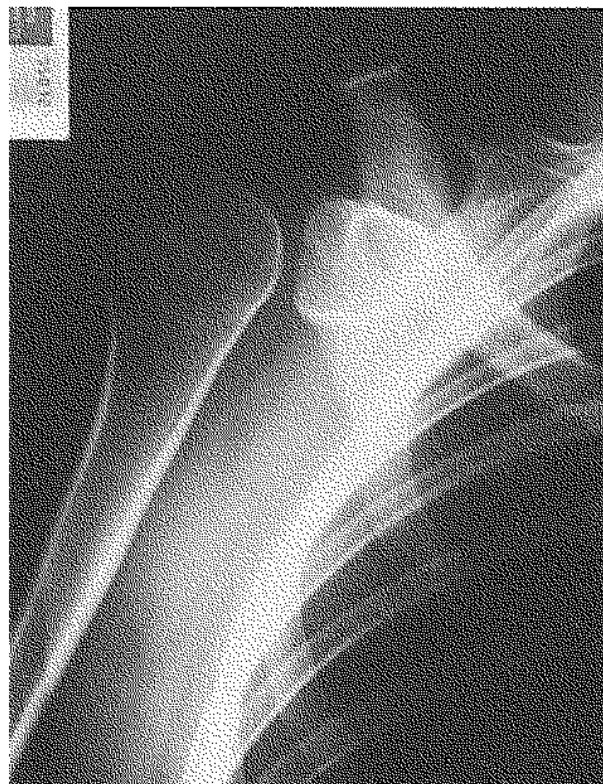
Radiograph of the shoulder with deformity of the humeral head and glenohumeral dislocation.
